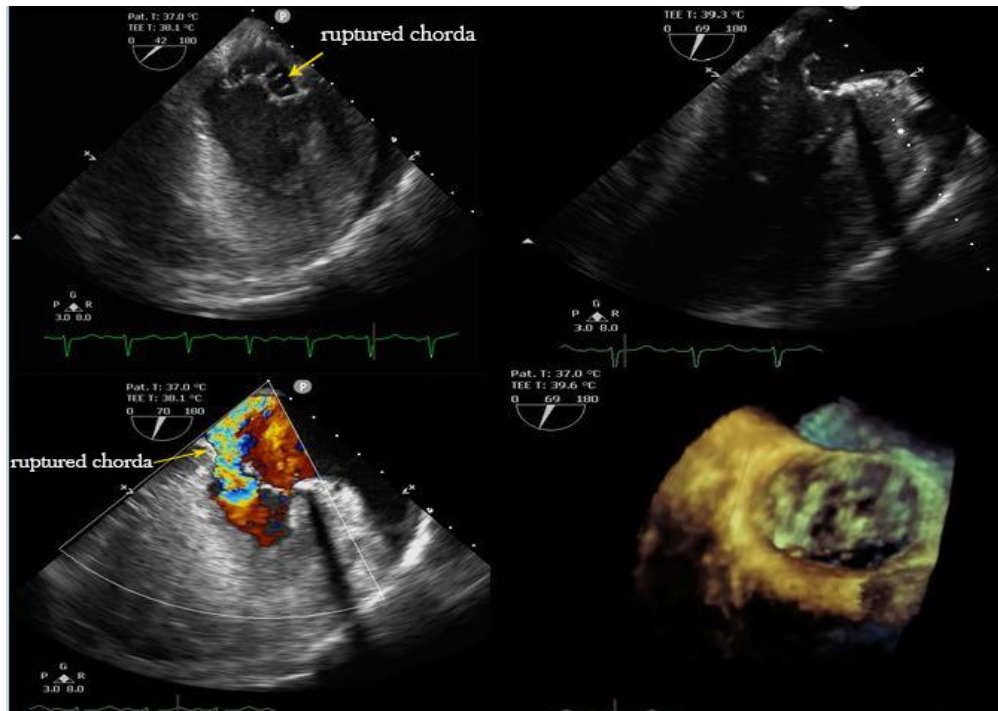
Transesophageal echocardiography, showing multiple ruptured chordae, resulting in a flail mitral valve and severe mitral regurgitation without any evidence of endocarditis
